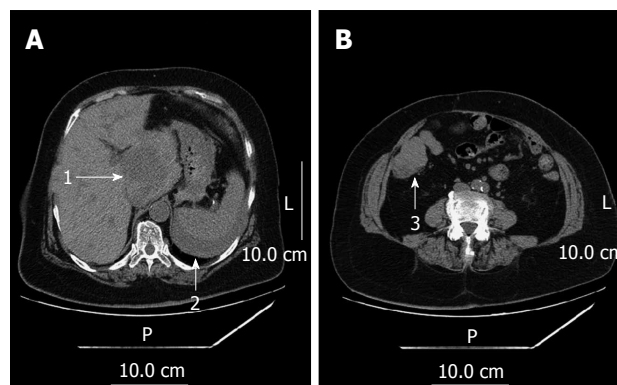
Urgent computed tomography. A: Sagittal view; B: Transverse view. 1: A ruptured mass of 6 cm × 6 cm × 6 cm localized in the I hepatic segment; 2: Perisplenic hemoperitoneum; 3: A 5 cm × 5 cm × 5 cm mass abutting the ileocecum without lymph node enlargement. L: Left; P: Posterior.
